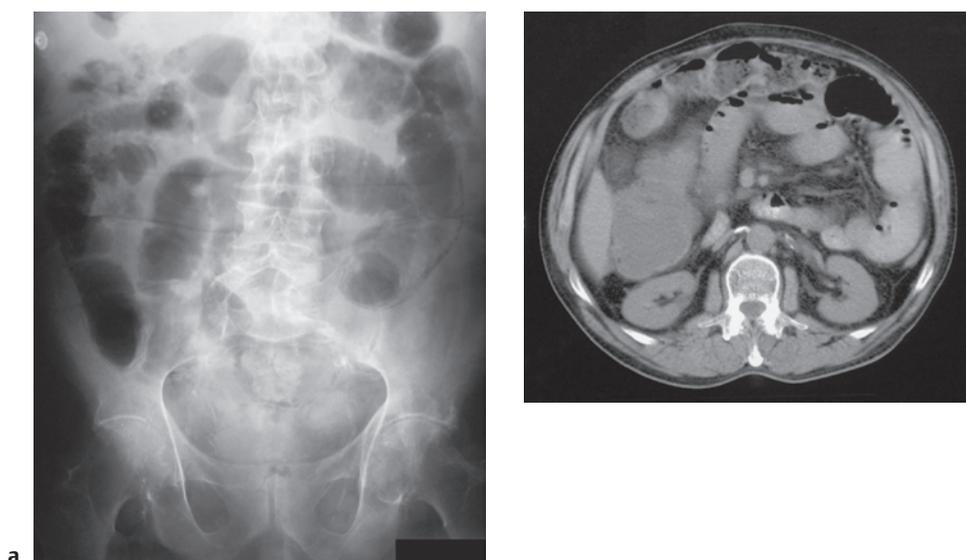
Pneumatosis cystoides. Radiograph may show a pearl-shaped or lamellar double contour (image provided courtesy of Dr.Volker Rempik, Institute for Radiology, Augsburg Clinic).
